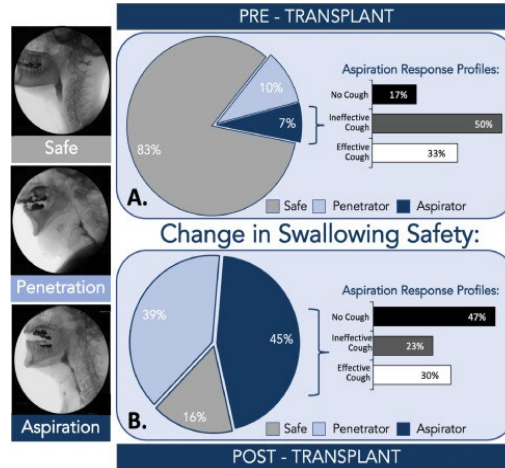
Comparison of swallowing safety profiles before (A) and after (B) lung transplantation in the 170 patients who underwent radiographic procedures at both time points. Representative examples of each safety classification are provided.
